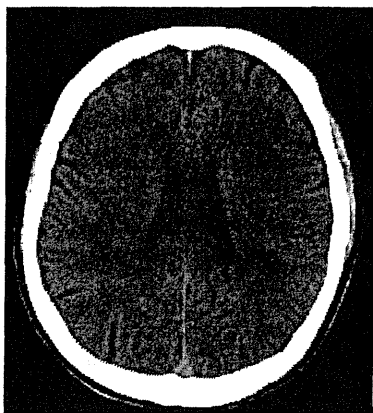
Brain computed tomography performed on the day of the onset of the symptoms showed an absence of abnormalities.
